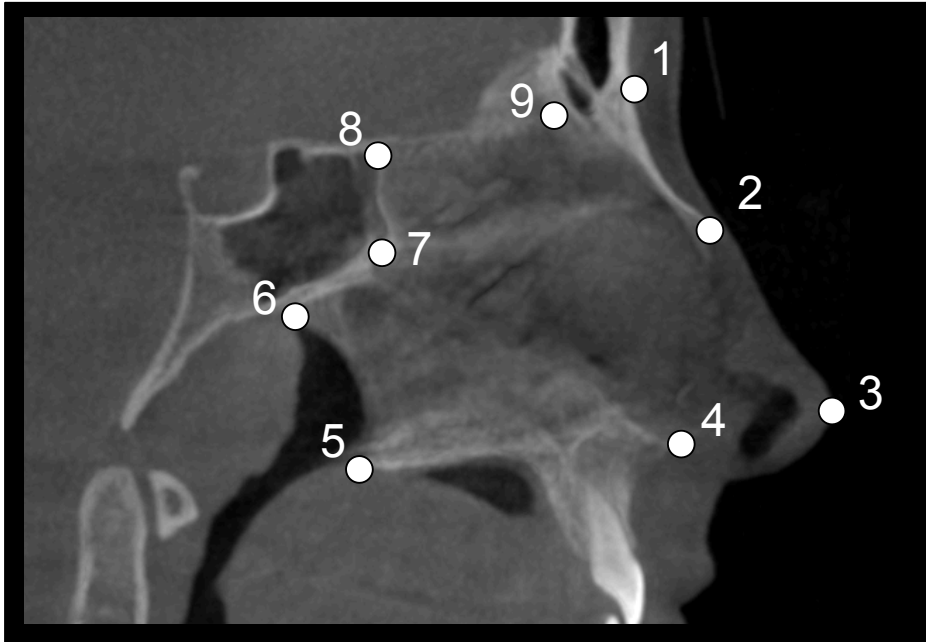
Landmarks used to quantify the size and shape of the nasofacial region in a midsagittal section of a cone beam computed tomography image. 1=nasion; 2=rhinion; 3=pronasale; 4=anterior nasal spine; 5=posterior nasal spine; 6=hormion; 7=anterior-inferior sphenoid body; 8=anterior-superior sphenoid body; 9=anterior cranial base.
